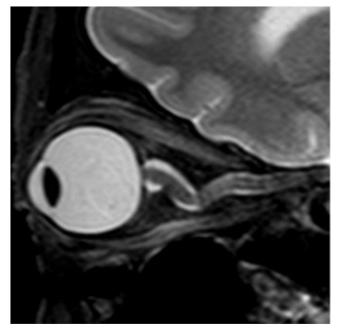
Sagittal T2-W1. Sagittal section of the orbit showing ONT in an astronaut postflight. MRI image provided by the Lifetime Surveillance of Astronaut Health (LSAH) Program, NASA Johnson Space Center.
